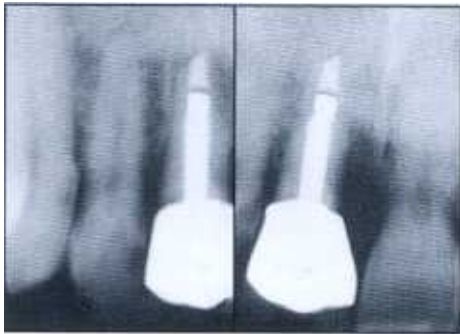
The fractured left central incisor was radiographically observed and a poor prognosis was determined.
